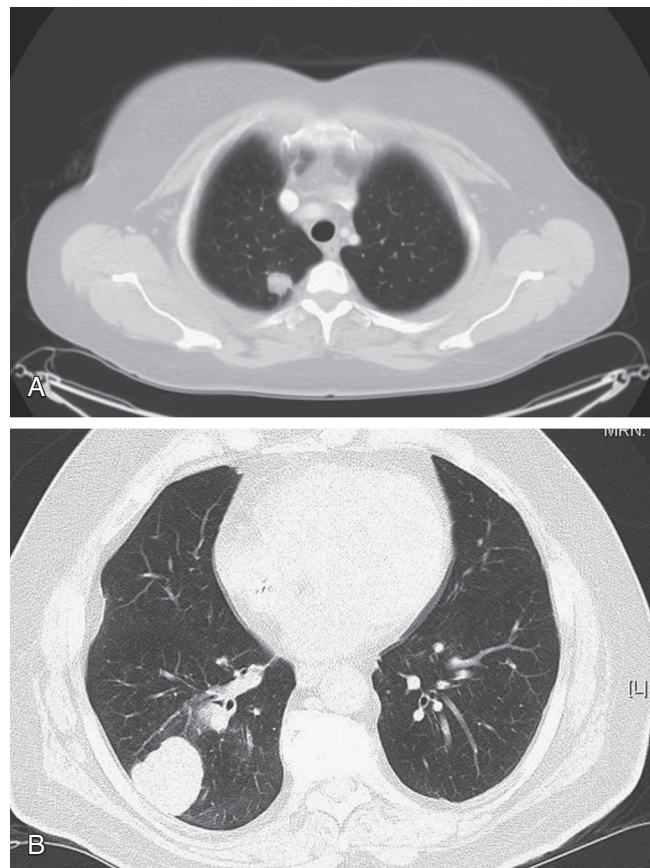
■ Pulmonary metastases as detected by chest CT. A, Metastatic lesion in the right upper lobe. B, Metastatic lesion in the superior segment of the right lower lobe.
